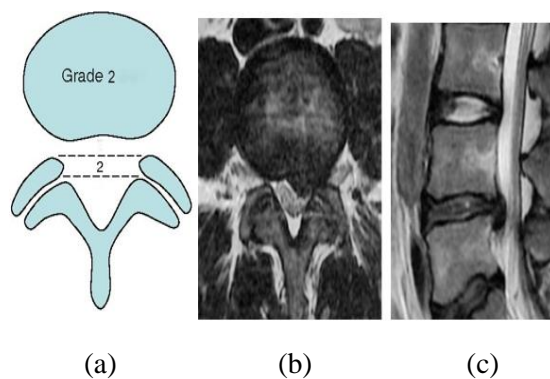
(a) Grade 2 disc herniation with medium impact on nerve compression, (b) MRI axial T2 weighted image and (c) sagittal T1 shows L4-L5 lumbar disc herniation.
